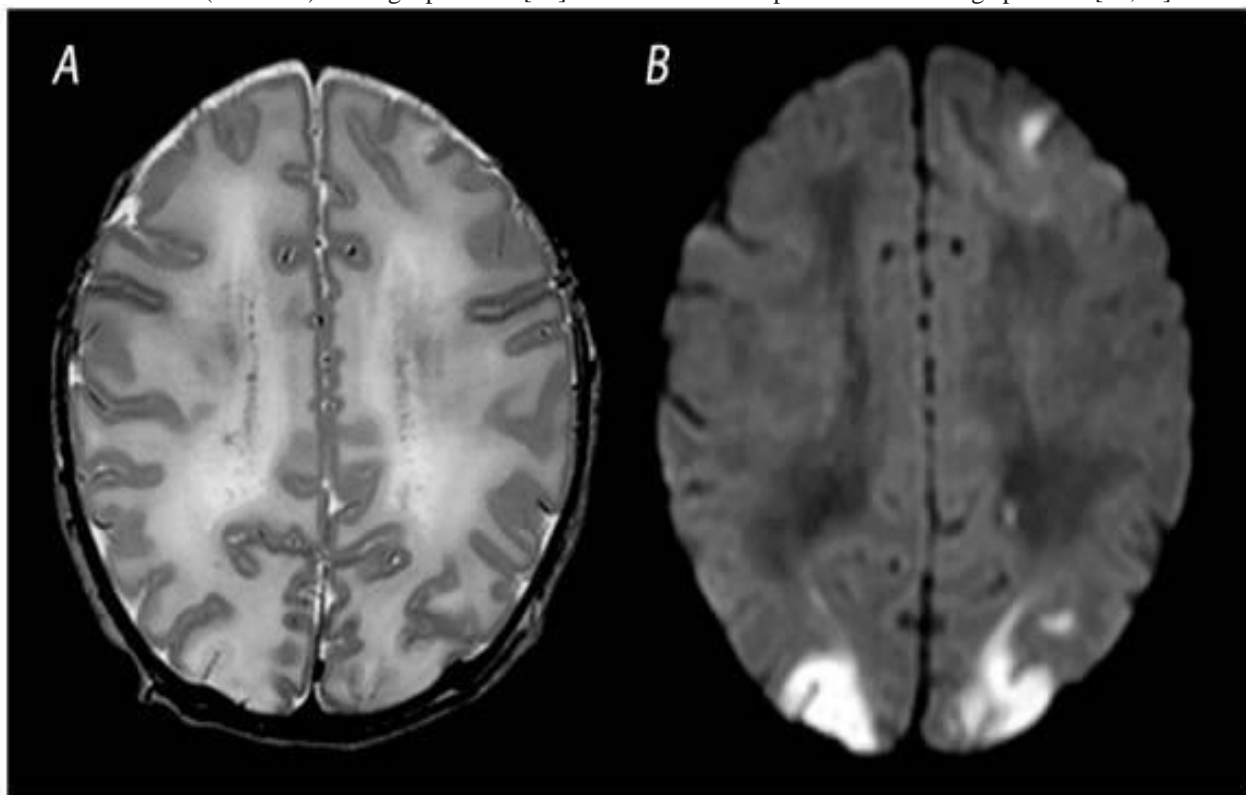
MRI was performed on day 4 in a term infant who was born with Apgar scores of 1/5. Amplitude integrated EEG initially showed a continuous normal voltage background pattern and cooling was not started.
